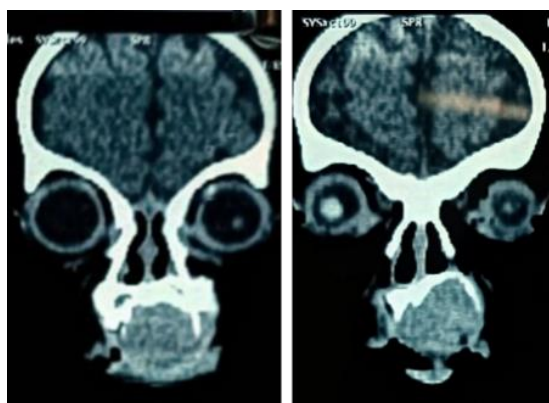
CT scan with contrast (coronal view)
